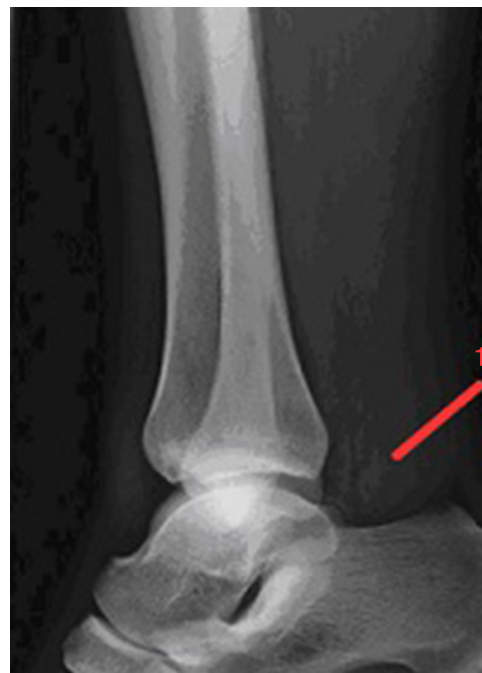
X-ray lateral ankle, obliteration of the Kager triangle for accessory soleus muscle.
